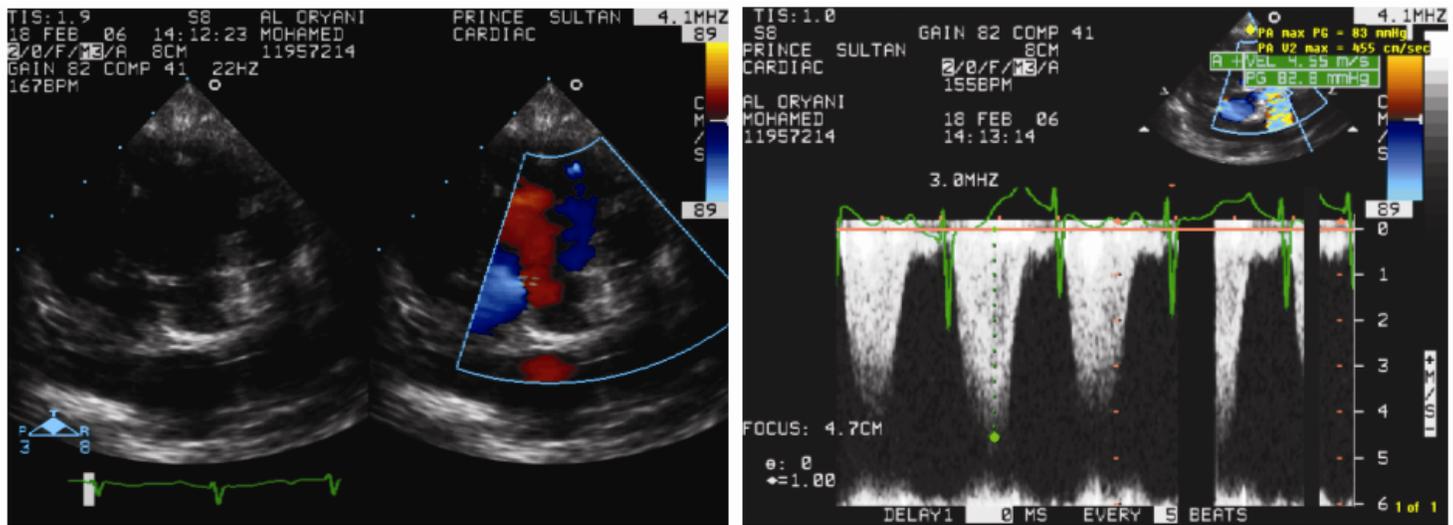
parasternal short axis view showing malaligned VSD with infundibular and pulmonic valve stenosis v max @ 4.5 m/s.
